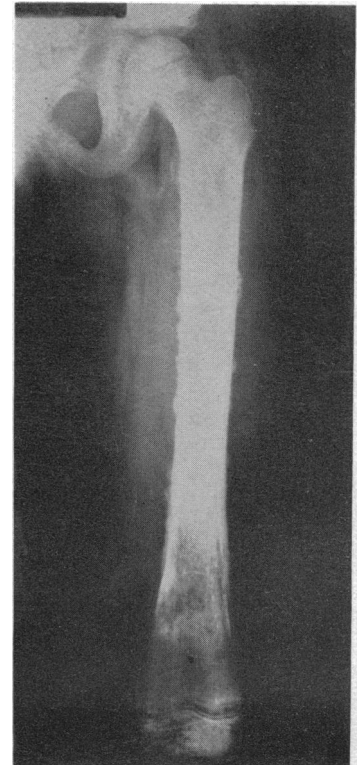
Radiograph of femur, showing periosteal irregularity and subperiosteal calcification.
